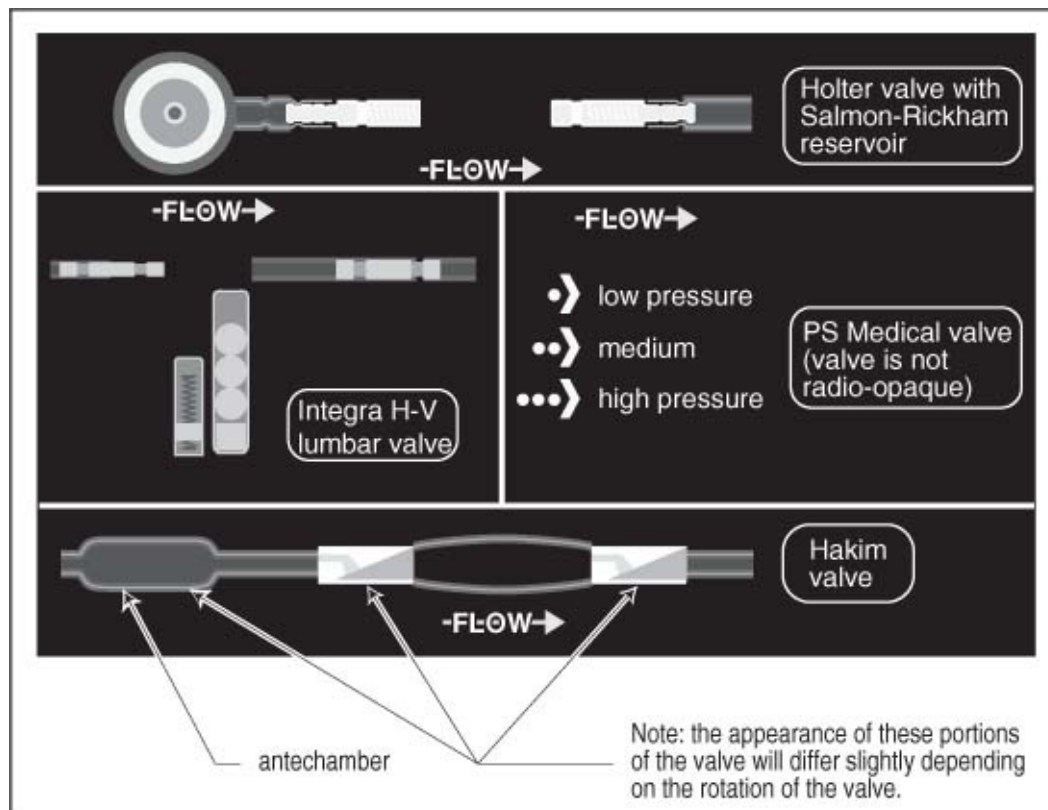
X-ray appearance of common shunts For x-ray appearance of programmable valves and the corresponding pressures, see the individual valve.
